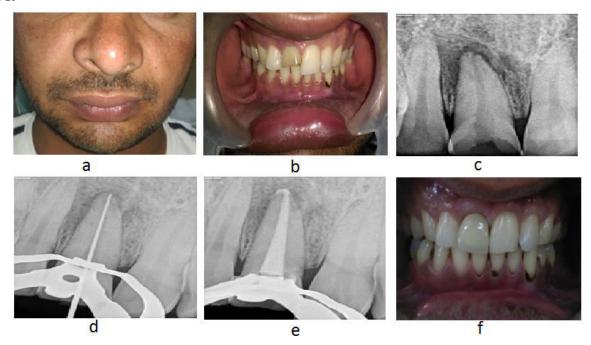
a-Extraoral swelling seen on the right side, 1.b- greyish discoloration of tooth 11; 1.c- preoperative radiograph; 1.d- working length radiograph; 1.e- obturation radiograph, 1.f- all ceramic crown placement.
